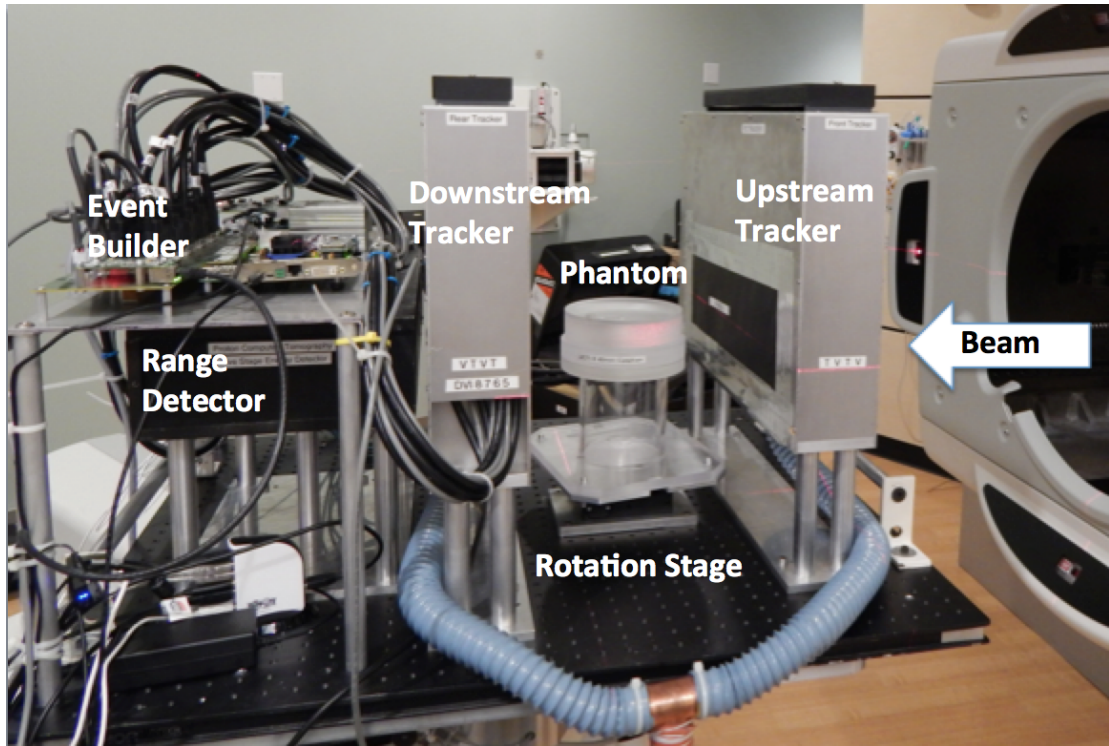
Photograph of the Phase-II proton CT head scanner in a proton beam line at the Northwestern Medicine Chicago Proton Center.
